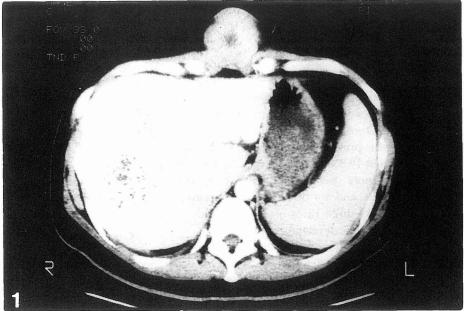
CT indicated a skin metastasis and large lipidol deposit in HCC occupying the right lobe.
